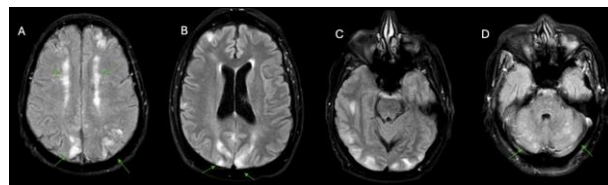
Posterior reversible encephalopathy syndrome (PRES) in the setting of renal failure. (A, B, C, D) Axial FLAIR MR images demonstrate bilateral symmetric cortical and subcortical hyperintensities involving both cerebral and cerebellar hemispheres, representing vasogenic edema typical of PRES. The distribution pattern shows the characteristic multifocal involvement beyond the classic parieto-occipital regions.
